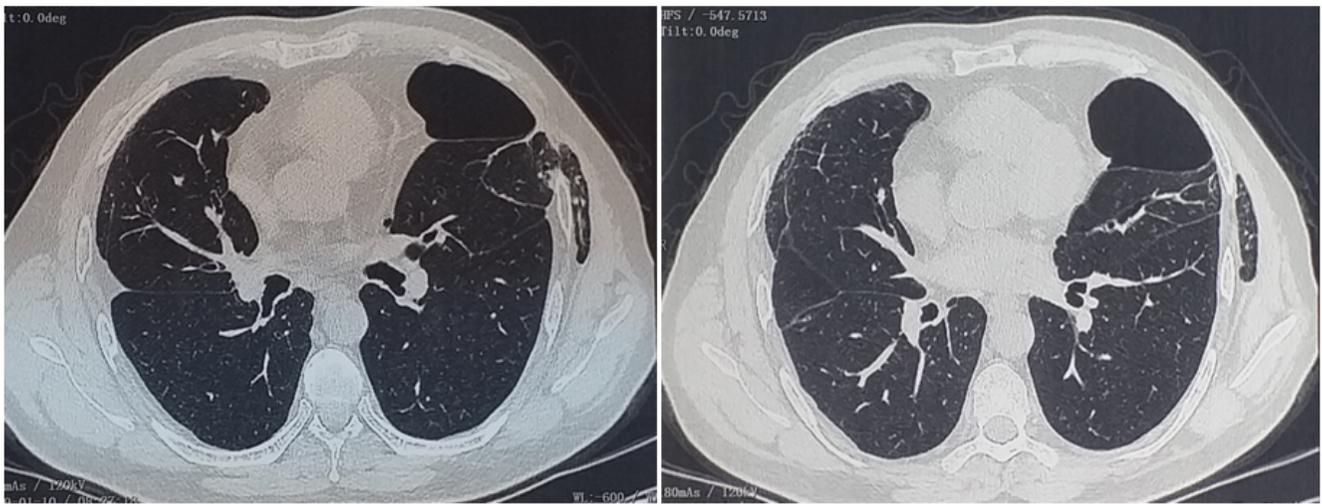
Computed tomography scan: intercostal lung hernia.
